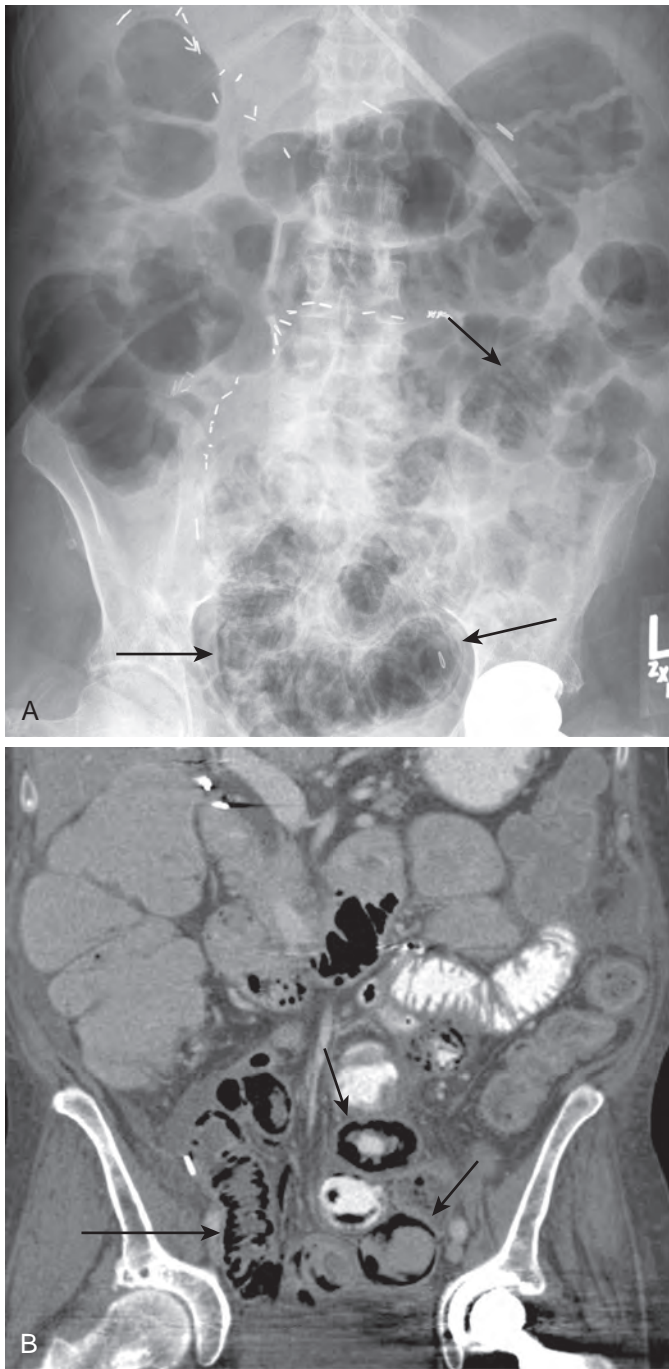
Black enhancement pattern. Plain abdominal x-ray (A) and MDCT scan (B) show intramural gas (arrows) in multiple loops of small bowel, 1 day after the operative placement of a jejunal feeding tube.
